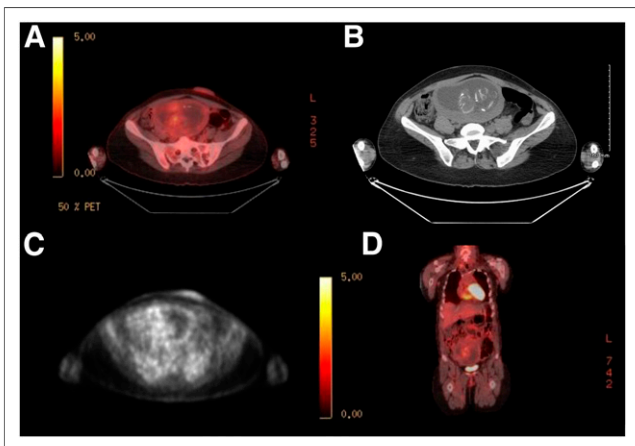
Images of pregnant patient: axial fused (A), axial CT (B), axial attenuation-corrected (C), and coronal fused (D).
